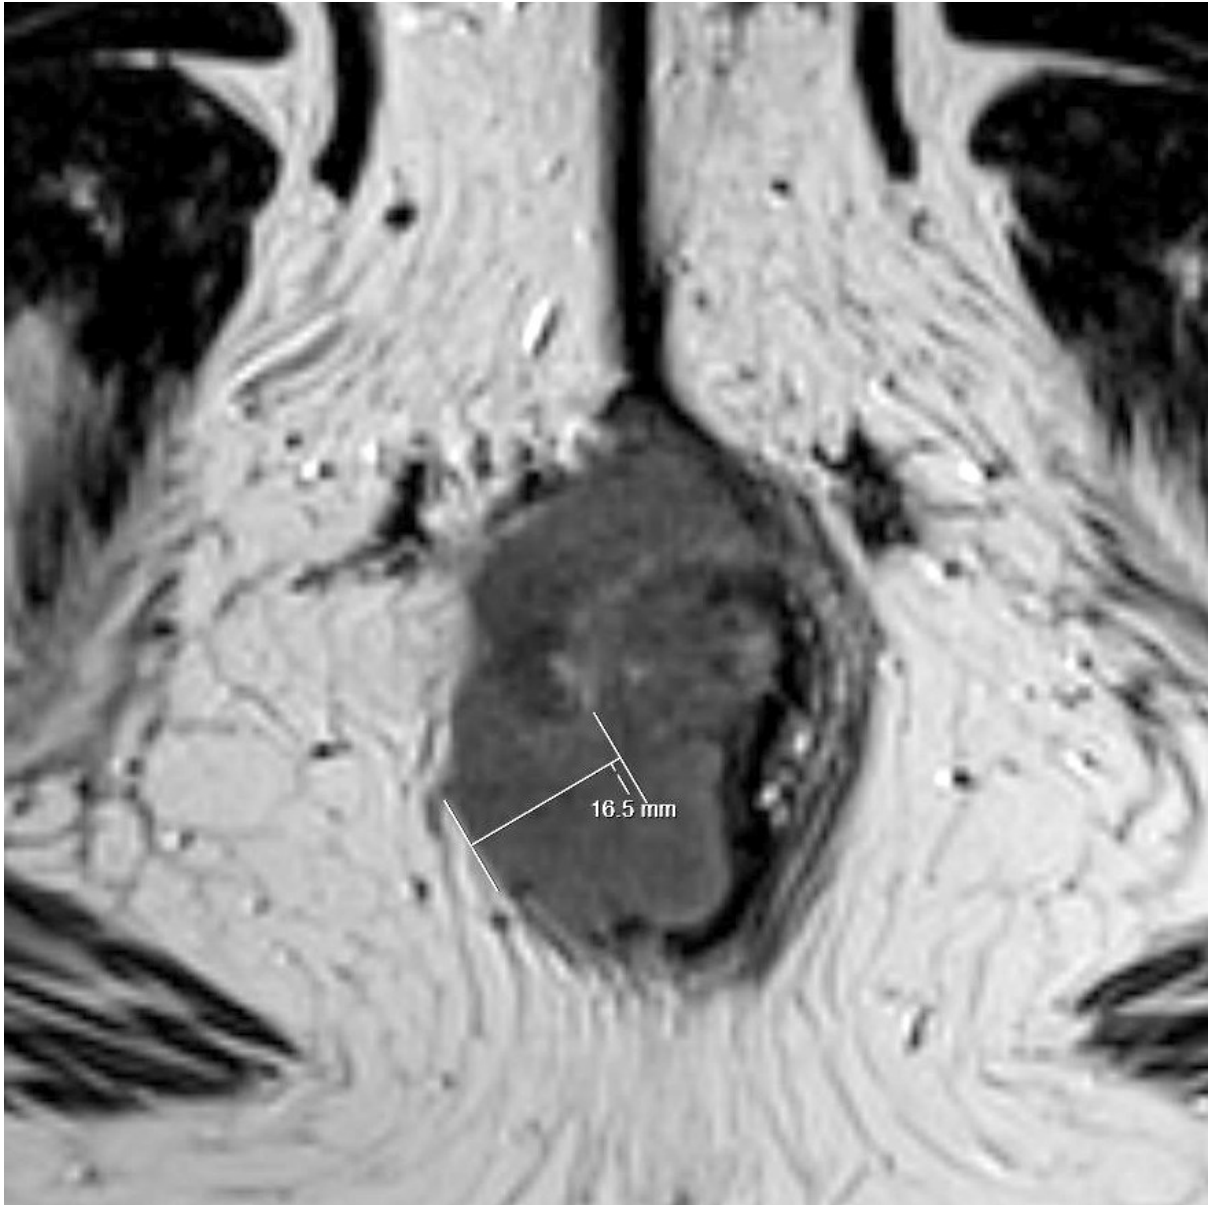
Example of how depth of extramural spread was measured on MRI (mrDEMS)
